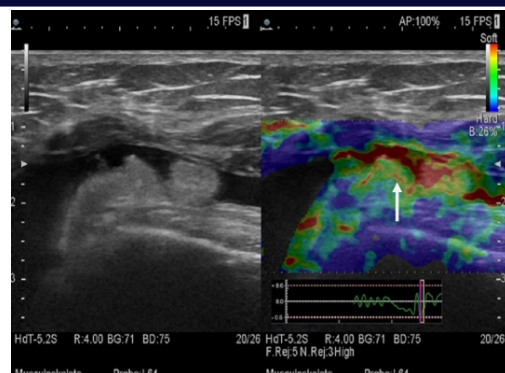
A frond like fatty mass in suprapatellar bursa with surrounding effusion. On elastography soft colours are seen suggestive of lipoma Arborescens (white arrow) confirmed later on MRI.
